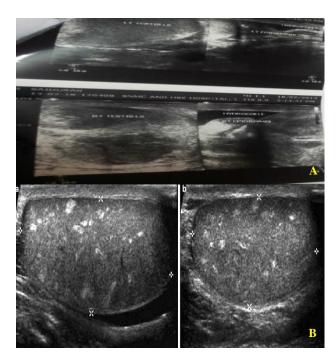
Ultrasound scrotum showing hypoechoic areas.
